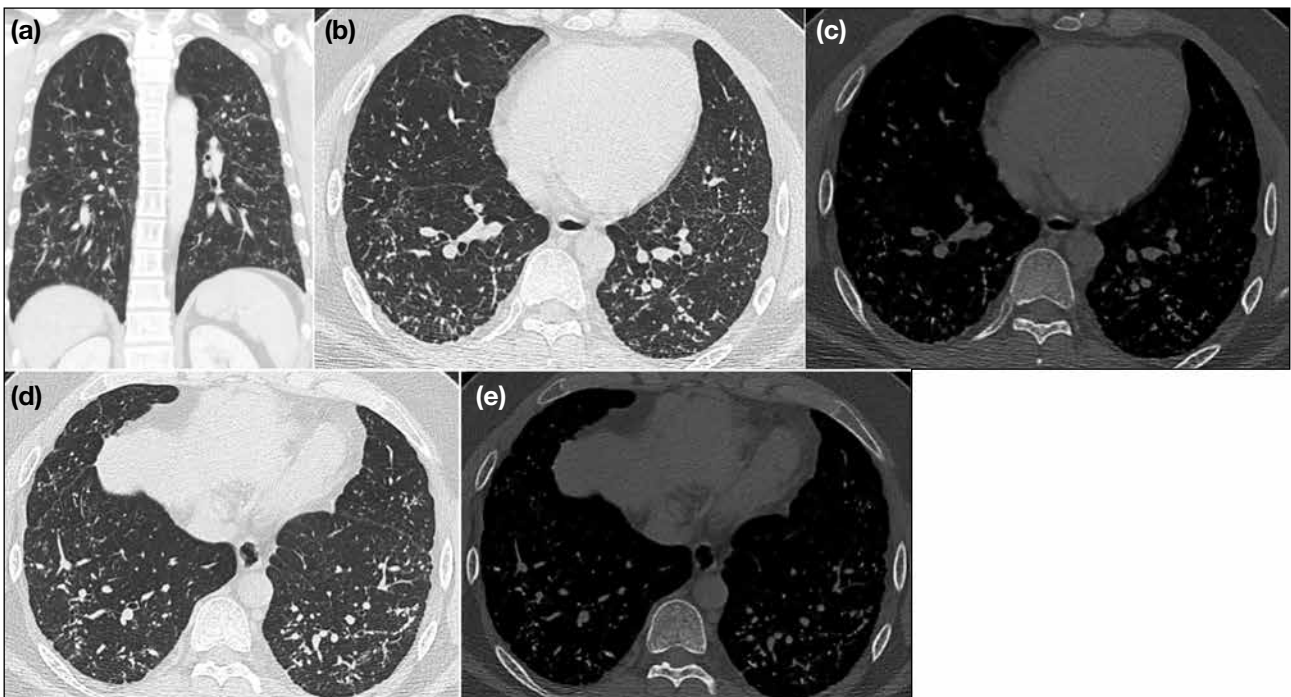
Computed tomography of the thorax with coronal reformatted image in the lung window (a). Axial images at T8 level in the lung (b) and bone windows (c), respectively. Axial images at T9 level in the lung (d) and bone windows (e), respectively. They show numerous small (<3 mm) pulmonary nodules with basal and peripheral predominance in the interstitial spaces, producing a branching 'dendriform' appearance. The calcific density of these nodules is more easily appreciated in the bone window.
